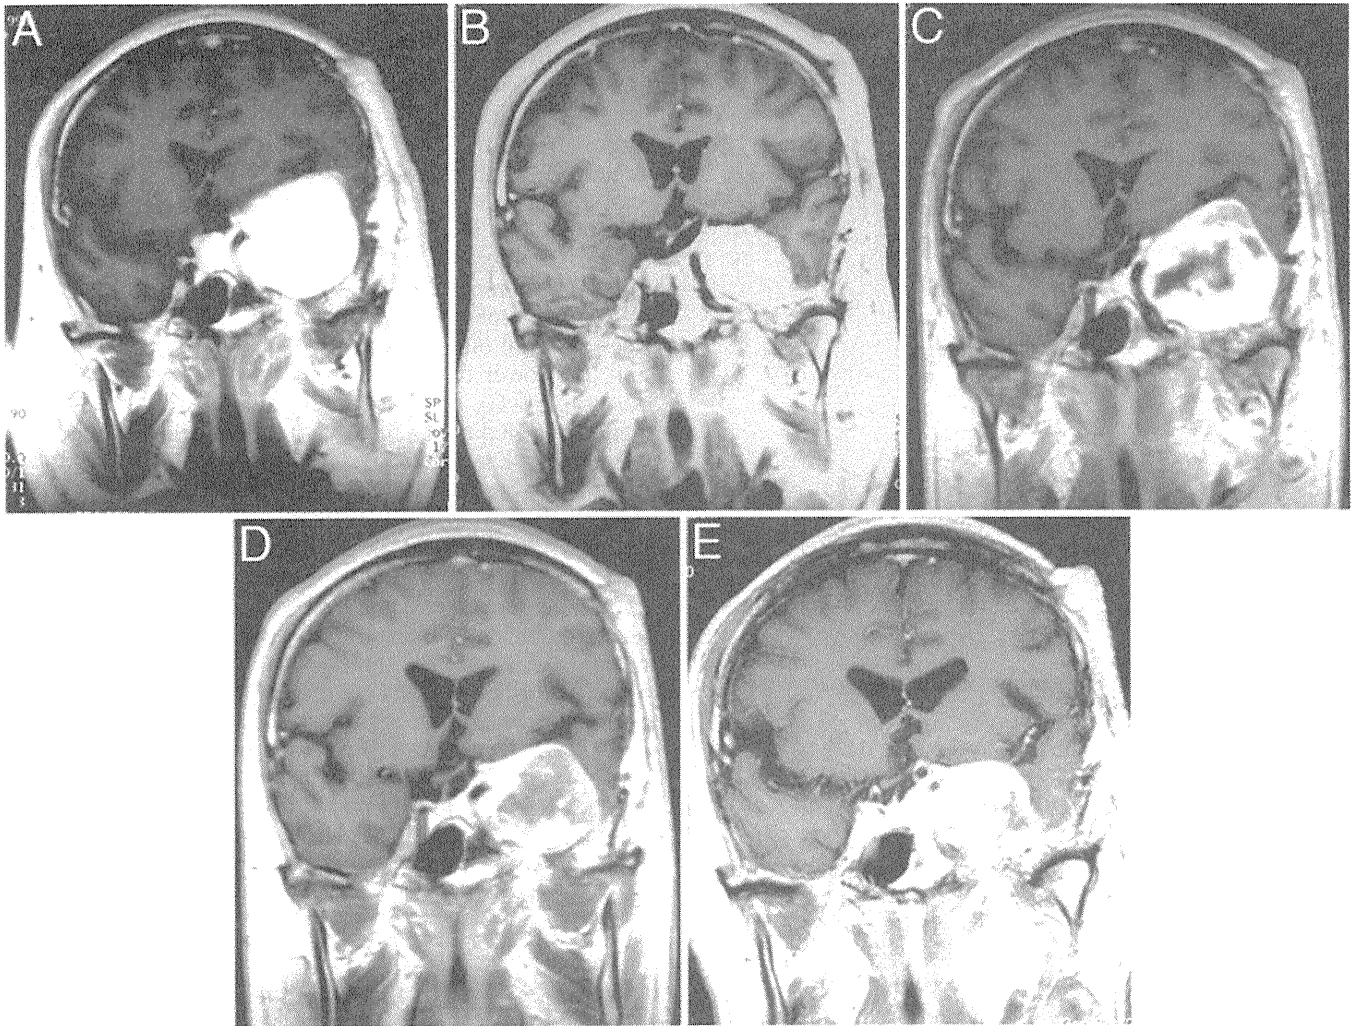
Case 14. Sequential contrast-enhanced coronal T1-weighted MR images obtained before the second surgery and radiation therapy (A), 31 months after treatment (B), 60 months after these treatments but before GKS (C), and 12 (D) and 84 months after GKS (E).
